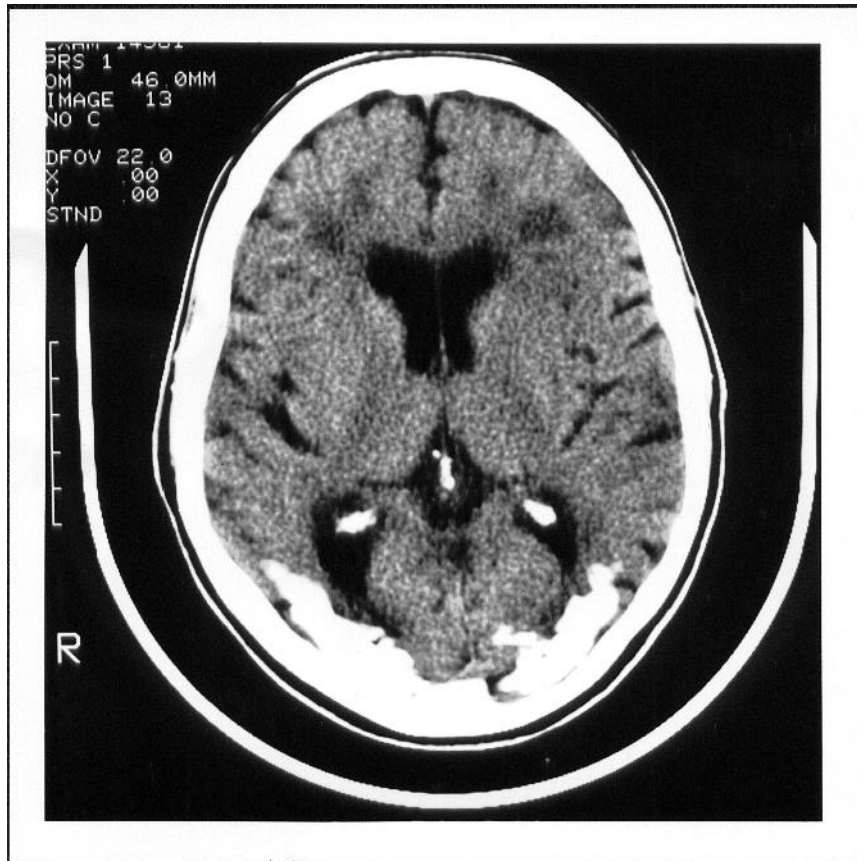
Computed tomography of the brain showing bilateral occipital calcifications in a patient with coeliac disease and epilepsy [photo courtesy of Dr Gordon Plant, The National Hospital for Neurology and Neurosurgery, Queen Square]
